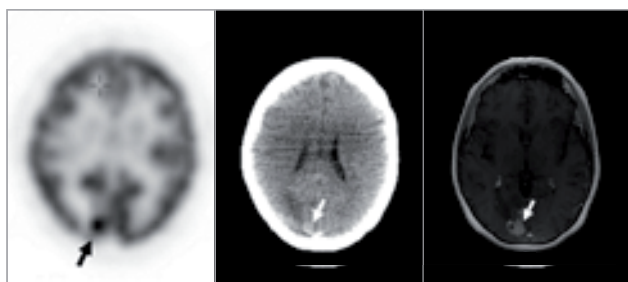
A. Patient No.18 with newly diagnosed solitary brain metastasis by PET/CT, in the right occipital lobe with hypermetabolic appearance on the PET scan (arrows). B. MRI revealed the lesion to be metastatic (arrow) and diagnosed at least 20 other subcentimetric lesions.
